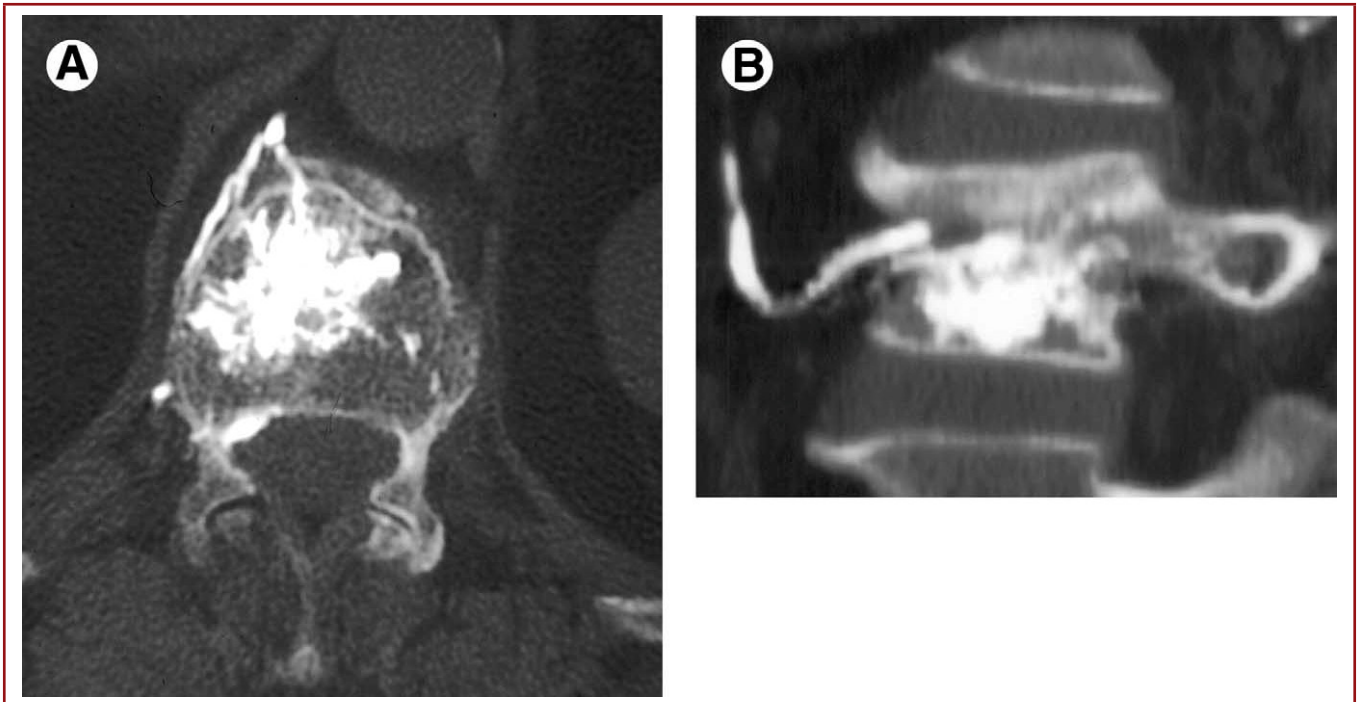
Postvertebroplasty CT scan with metastatic vertebral fracture. Axial scan showing prevertebral venous cement leakage (A). Sagittal reformatted image showing prevertebral venous cement leakage (B).
